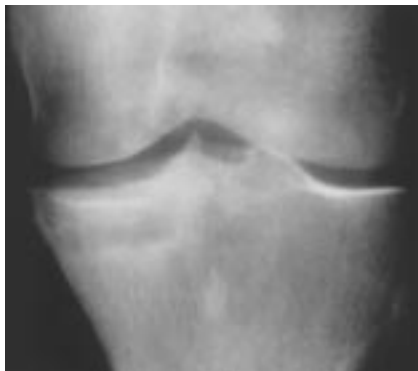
Plain radiograph of the medial tibial plateau shows a subchondral area of lucency surrounded by sclerosis.
